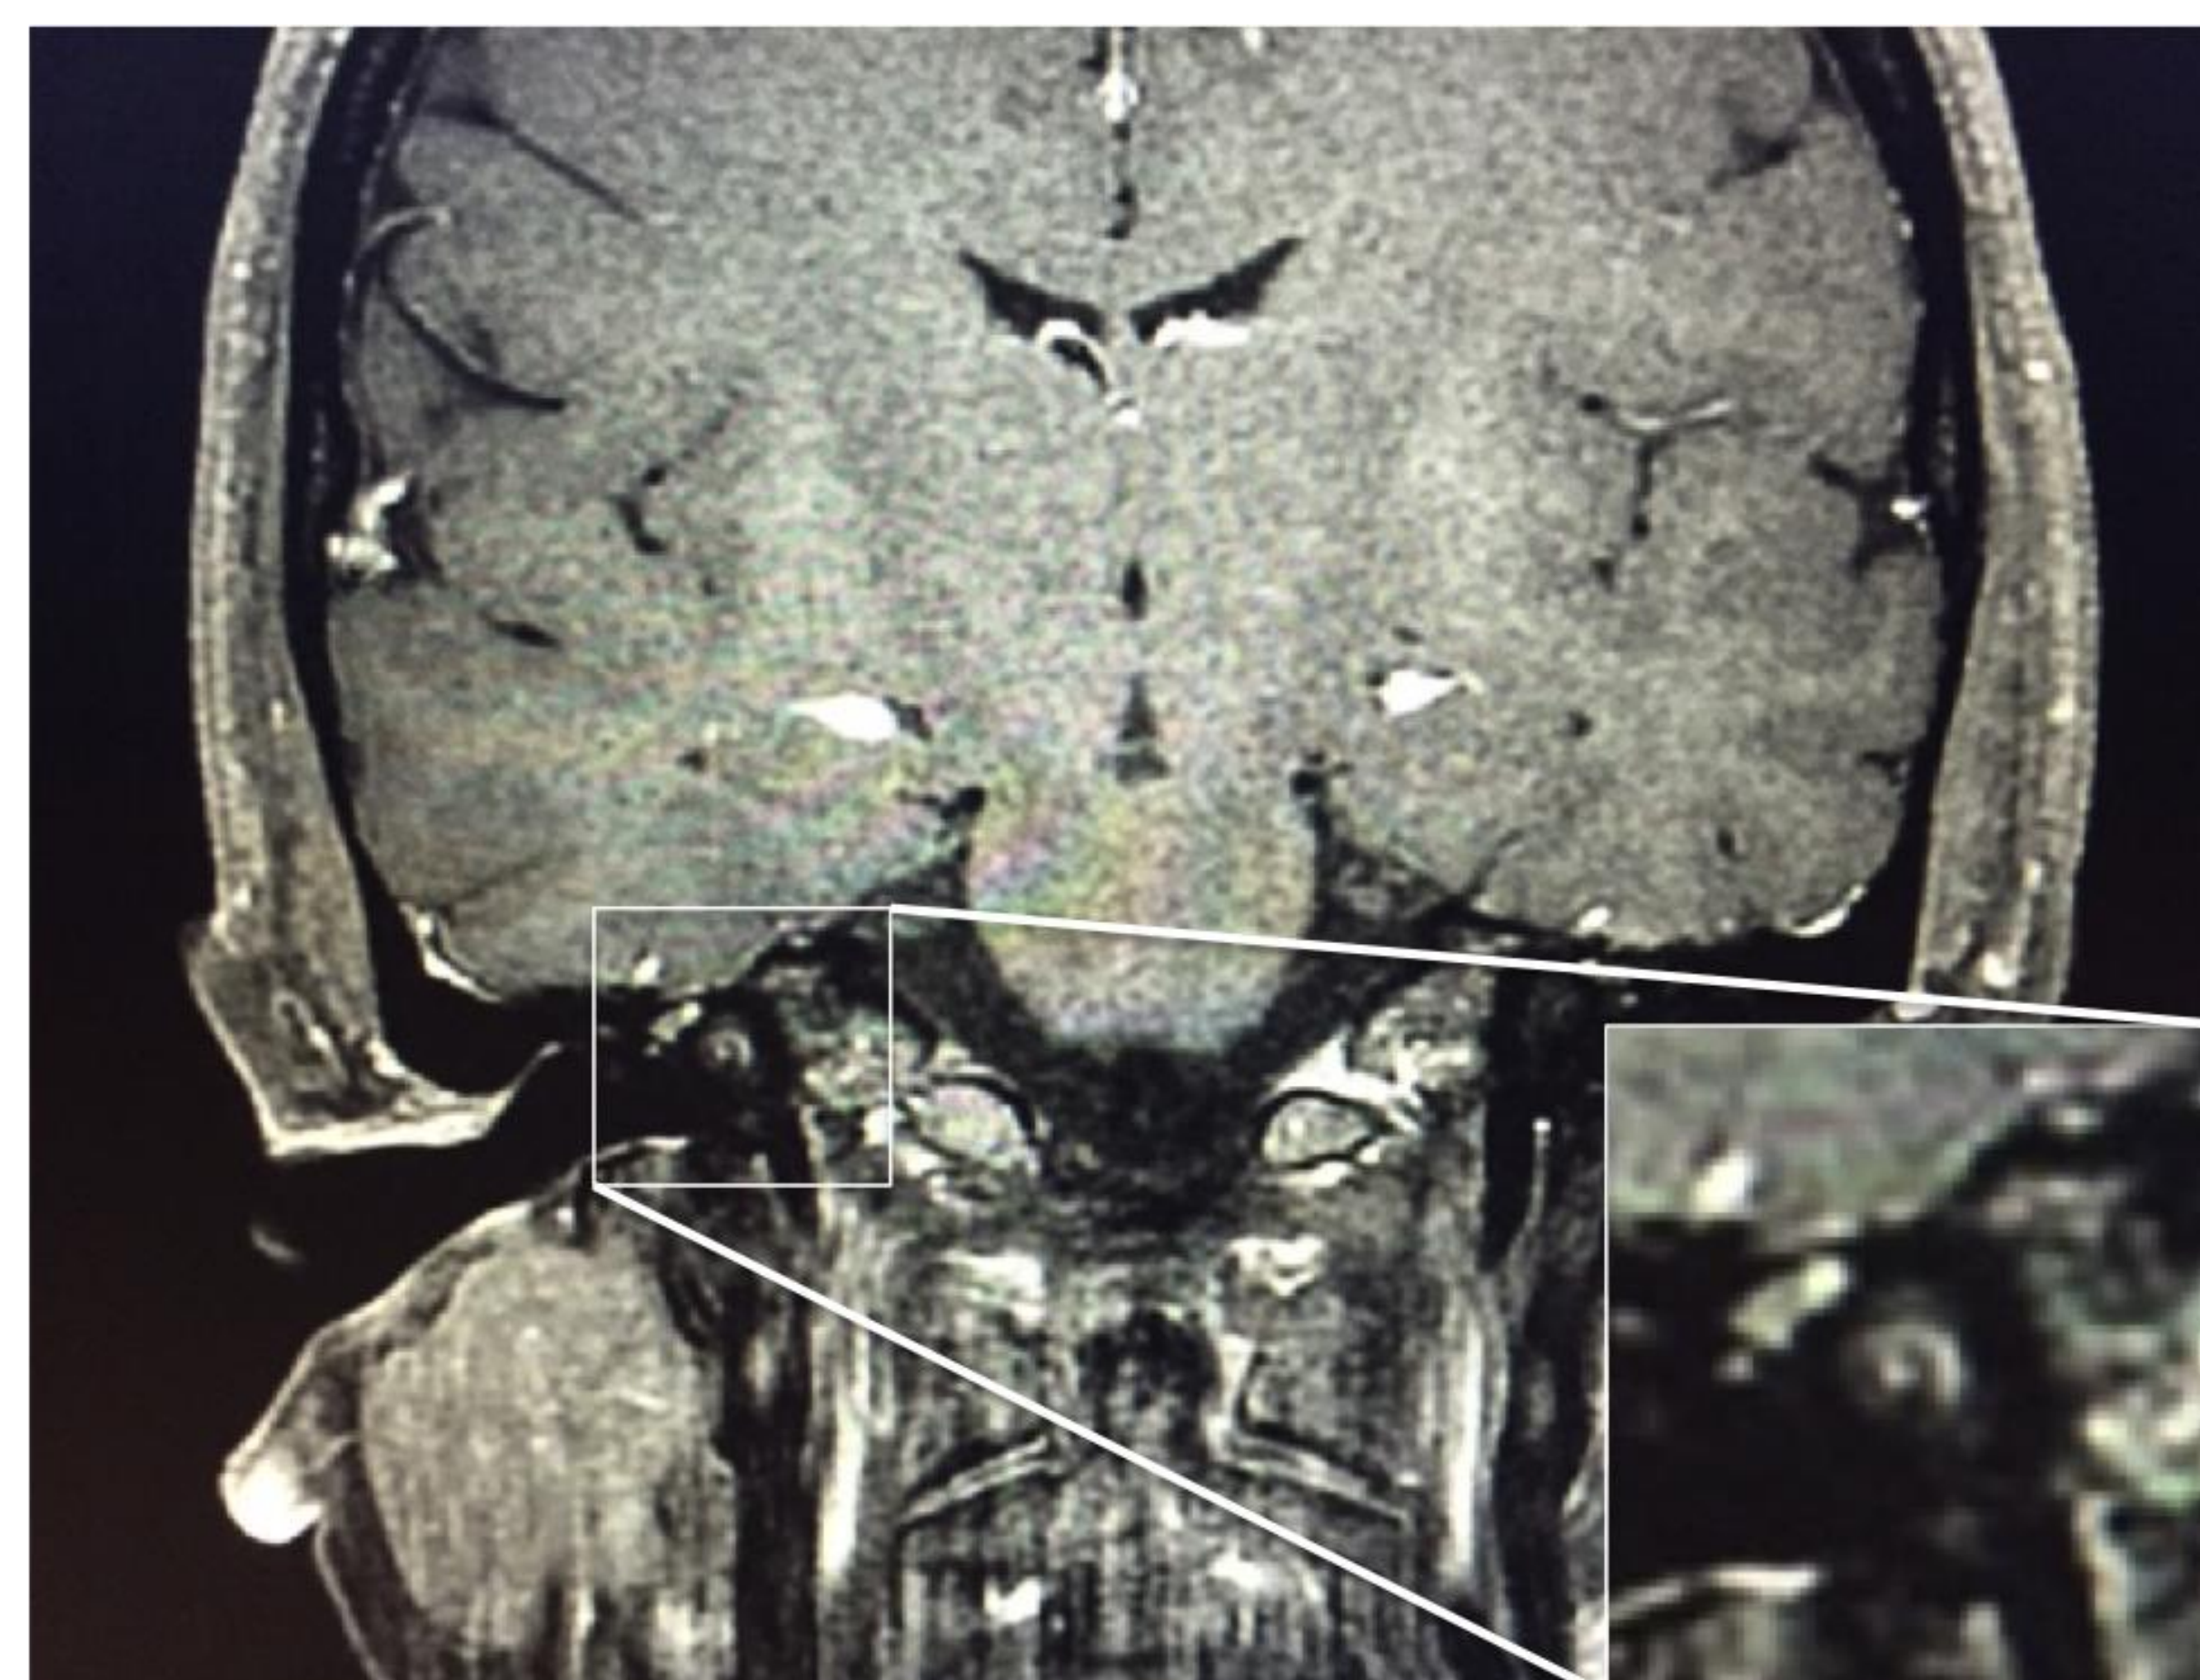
Coronal T1-weighted post-gadolinium with fat saturation. The spiral of the cochlea can be seen distinctly on this image. An enlarged image of this finding is shown in the lower right corner.
